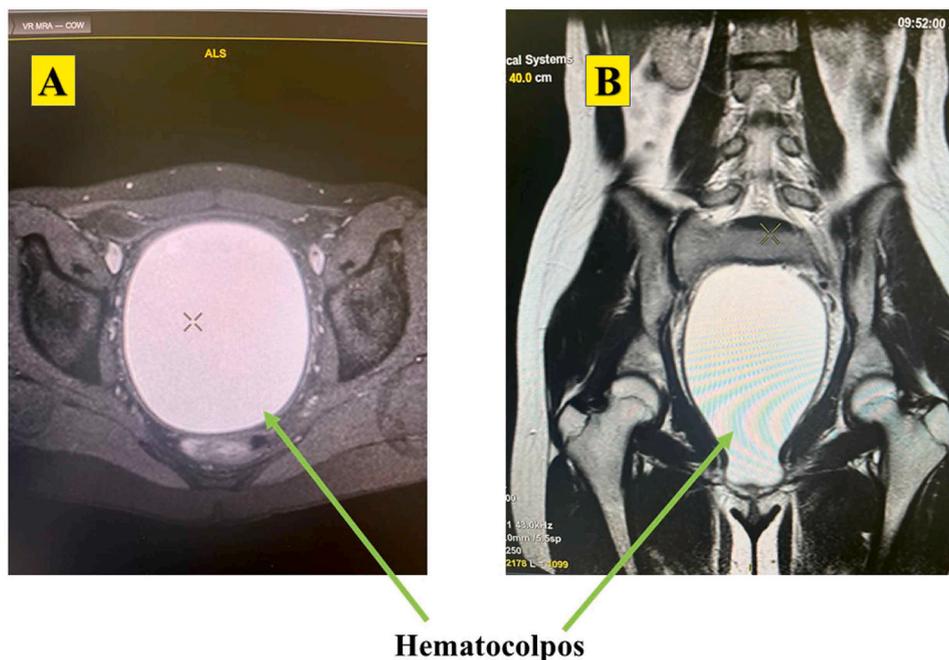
(A) Axial T1 weighted image; (B). Coronal T2 weighted image of the pelvis. Conventional abdominal MRI protocols cover various T1-weighted (T1W) and T2-weighted (T2W) data collecting techniques [7]. Fig. 1: A and B images depicts the presence of a hyperintense mass in the pelvis. According to reports, T1 hyperintense regions are a useful indicator for differentiating between hemorrhagic masses [8]. In Fig. 1B shows a hyperintense mass which reach the margin of external genitalia. This could indicate the presence of either blood, pus or serous fluid. The condition of the uterus, cervical canal, vaginal canal, and the existence of any T2W hypointense septa in the uterus, cervix, or vagina are all revealed through true coronal images [9].
